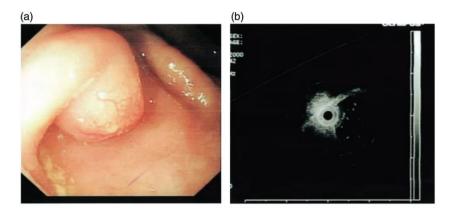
Endoscopic and ultrasonographic findings. (a) Endoscopic appearance of appendiceal granular cell tumor: smooth protuberance of about $1.0 \times 0.8 \, \mathrm{cm}$ in size and (b) Endoscopic ultrasound findings of granular cell tumor: hypoechoic, smooth, homogenous mass.
